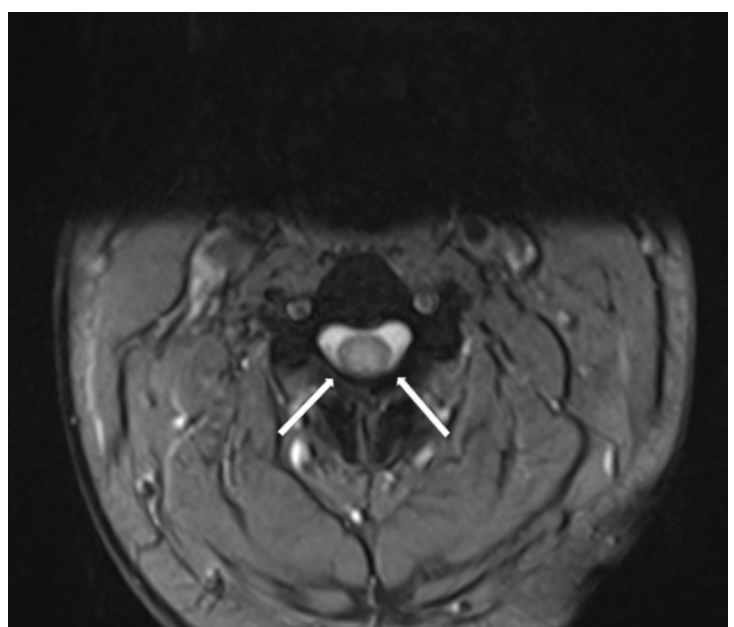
Axial T2-weighted image of the cervical spine showing a hyperintense signal (arrows) within the dorsal column of the spinal cord
